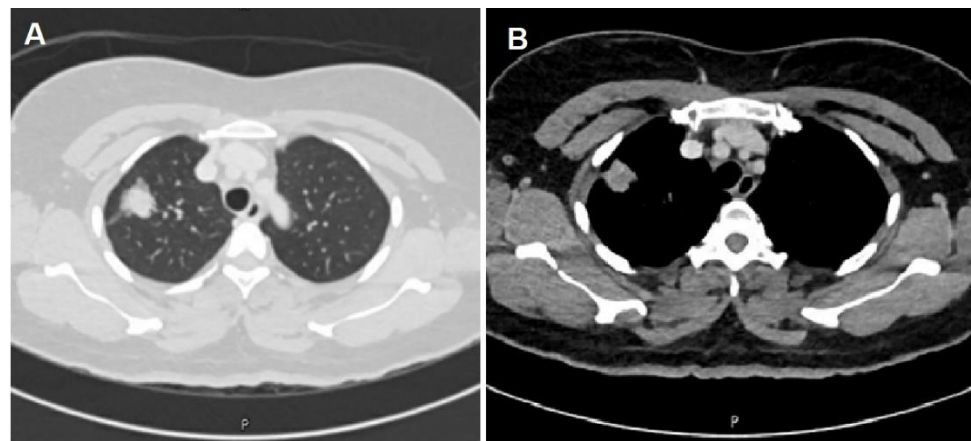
Section of Chest CT scan in lung window (A), and mediastinal window (B) and showed redemonstration of previously noted right upper lobe apical segment peripherally located lobulated lesion, predominantly solid with internal bubble-like lucency and surrounding halo of groundglass opacity and speculations now measuring about 24 x 25 x 26 mm in overall size. There appears to be interval increase in size of the solid part of the lesion which now measures 20 x 18 x 24 mm compared to 15 x 11 x 16 mm in figure 1.
